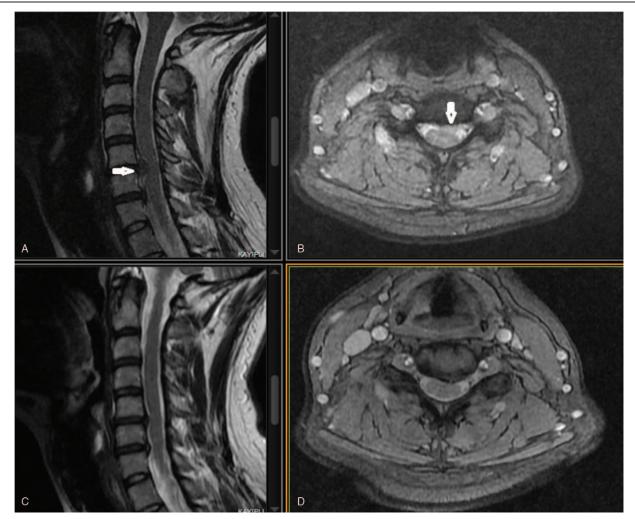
Of case 11, (A,B) Sequestered CDH on sagittal and axial spinal cervical MRI on admission (white arrow). (C,D) Resorption image of the disc on control spinal cervical MRI. CDH = cervical disc herniation.
